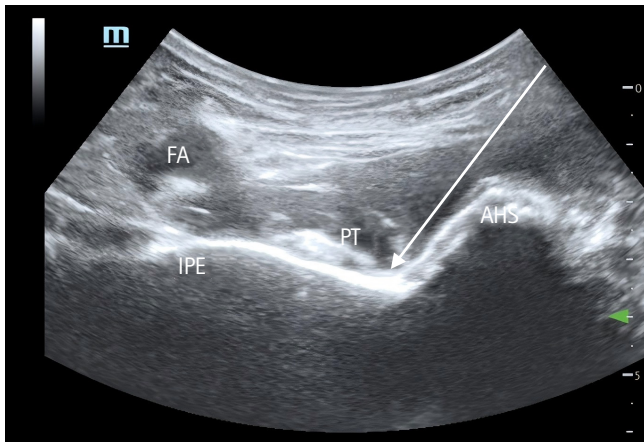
Ultrasound-guided pericapsular nerve group (PENG) block. The white arrow indicates the trajectory of the needle. AIIS: anterior inferior iliac spine, FA: femoral artery, IPE: iliopubic eminence, PT: piriformis tendon.
